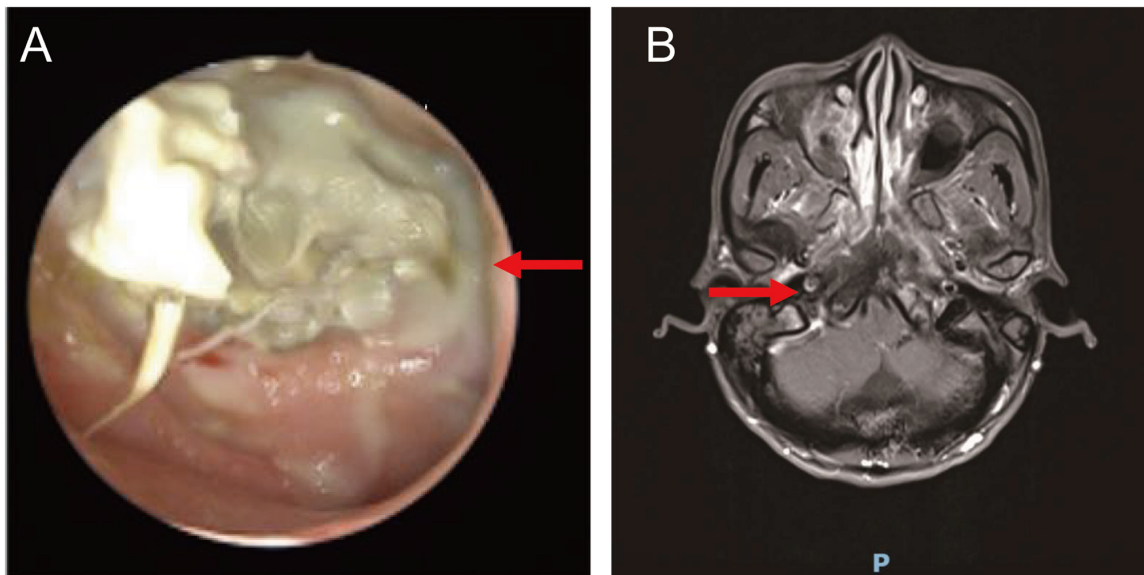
Images before treatment of case 2. (A) The image obtained with the use of a nasopharyngoscope showed a large amount of necrotic tissue on the posterior wall of the nasopharynx, surrounded by dead bone (red arrow). (B) Transverse, contrast-enhanced, T1-weighted MRI revealed necrotic lesions at the right side of the nasopharynx (red arrow).
